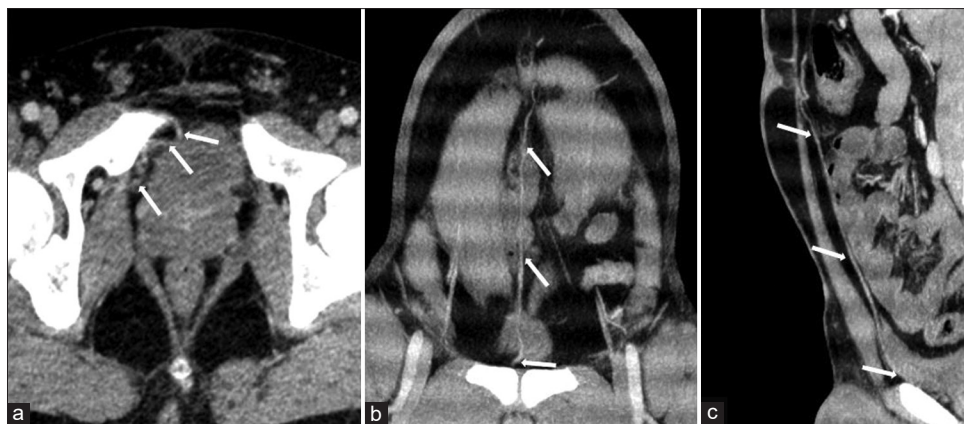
Axial (a), coronal (b), and sagittal (c) contrast-enhanced abdominal computed tomography images demonstrate the retropubic venous plexus (a, arrows) and its superiorly ascending midline collateral vein extending along the median umbilical fold (b and c, arrows)
